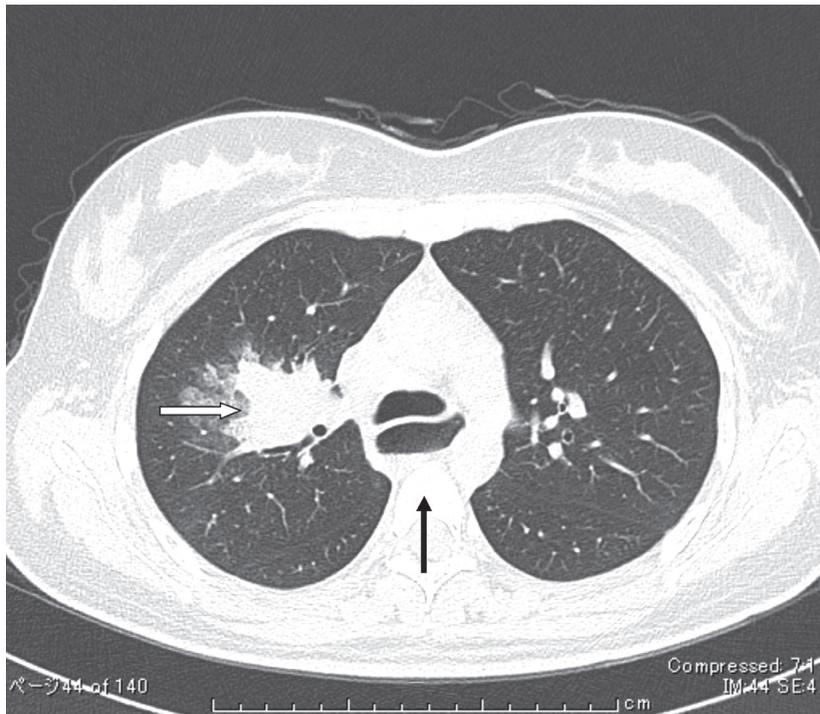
Chest CT Scan Showing Right Lung Infiltrate (White Arrow) and Moderately Dilated Esophagus (Black Arrow)
